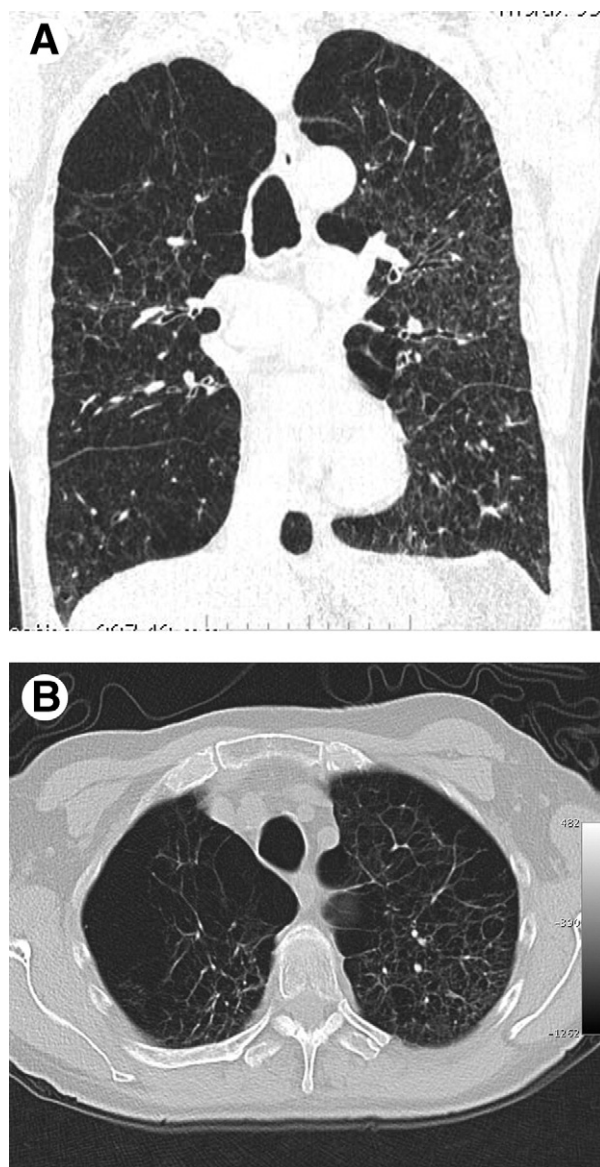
A preoperative chest computed tomography scan shows severe apical bullous lung disease, with right-sided predominance. CT images were unavailable at the time of the transplant. (A) Coronal and (B) transverse.
